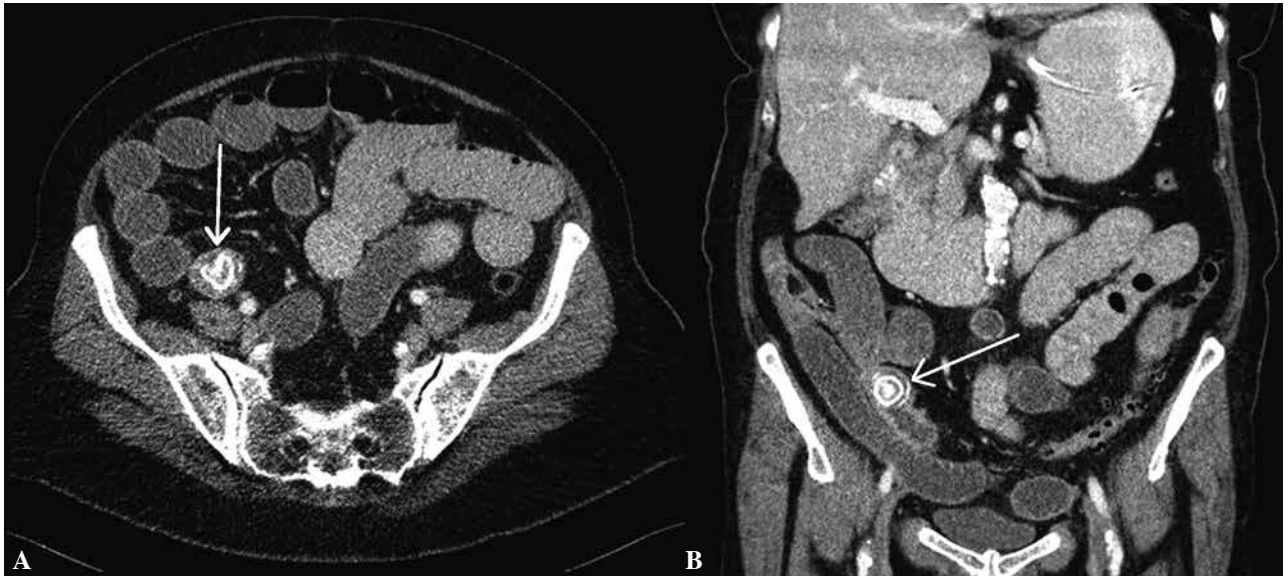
CT-scan demonstrating a mechanical small bowel obstruction by a gallstone, 8.0 cm before Bauhin's valve. A. Transversal plane, B. Coronal plane.
